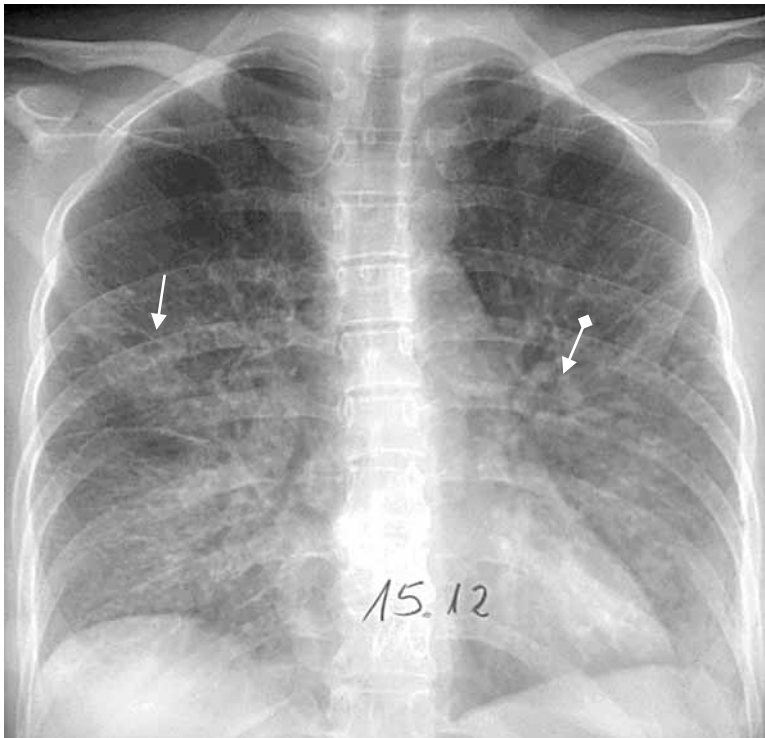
The survey radiograph of a thorax in direct projection. Structure of hilum of both lungs is indistinct. Interstitial lung patterns (as a linear and reticular pattern) of both lungs is intensified and deformed in the middle and inferior departments (arrow). In the hilum region of left lung nodules of small intensity (arrow with rombus).
